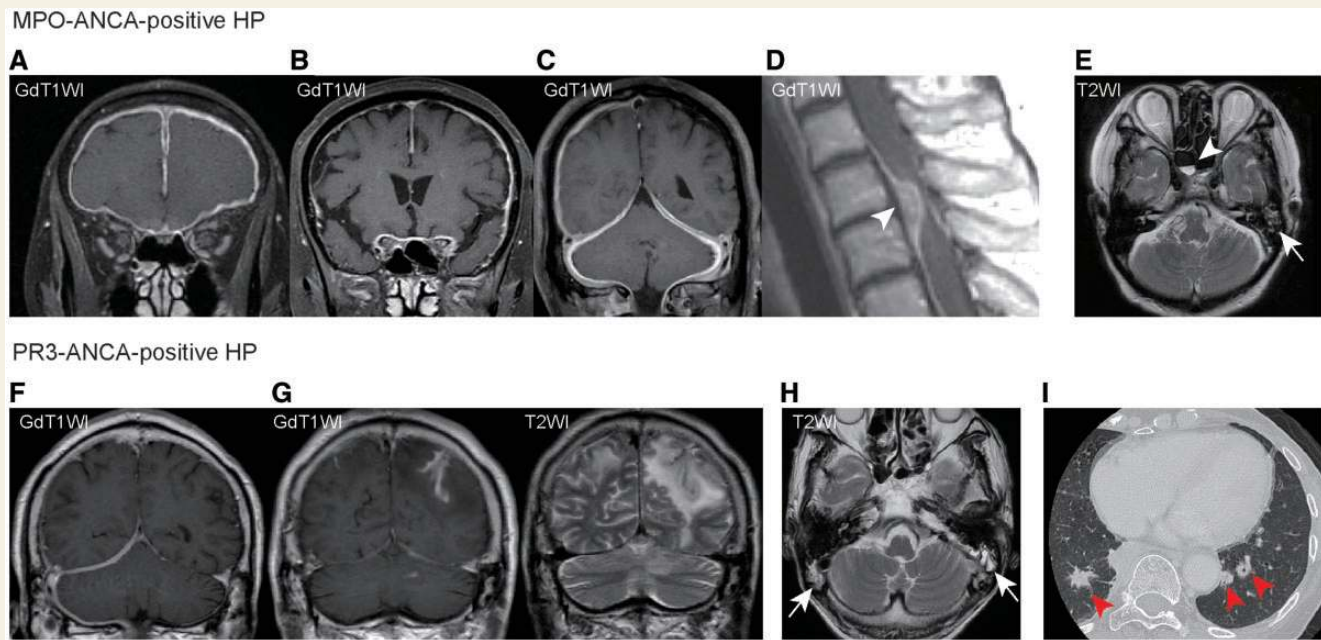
Radiological profiles of MPO-ANCA-positive hypertrophic pachymeningitis. In radiological studies, extra-axial enhancement in the CNS is classified as either pachymeningeal or leptomeningeal (Smirniotopoulos *et al.*, 2007). Pachymeningeal pattern of enhancement involves the dural reflections of the tentorium cerebelli, cranial fossa, cavernous sinus, falx cerebri, convexity, and the spine, whereas leptomeningeal pattern of enhancement occurs along the pial surface of the brain, and fits the subarachnoid spaces of the sulci and cisterns. Thickened dura mater (a pure pachymeningeal pattern of enhancement) was seen in tentorium cerebelli, cranial fossa, cavernous sinus, falx cerebri, convexity, and the spine (arrowhead) in patients with MPO-ANCA-positive hypertrophic pachymeningitis (A–D) and PR3-ANCA-positive hypertrophic pachymeningitis (F) on T₁-weighted post-gadolinium magnetic resonance images (GdT1WI). Thickened dura mater with leptomeningeal and parenchymal involvement (pachymeningeal and leptomeningeal patterns of enhancement) in the brain was significantly more common in PR3-ANCA-positive hypertrophic pachymeningitis (G) compared to MPO-ANCA-positive and idiopathic hypertrophic pachymeningitis (see Fig. 1D). Mastoiditis (arrows) and sinusitis (arrowhead) were observed in patients with MPO-ANCA-positive hypertrophic pachymeningitis (E) and PR3-ANCA-positive hypertrophic pachymeningitis (H) on axial T₂-weighted magnetic resonance images (T2WI). Nodular lesions (arrowheads) were observed in the lung of patients with PR3-ANCA-positive hypertrophic pachymeningitis on CT scans (I).
